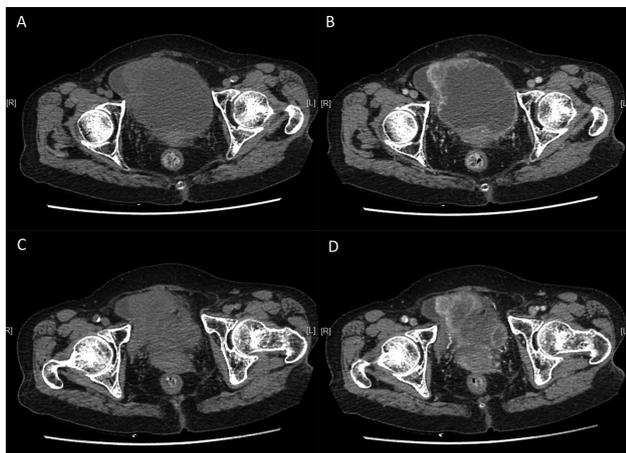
CT showing large pelvic tumour. (A, C): Pelvic routine scan. (B, D): Pelvis enhanced scan.
